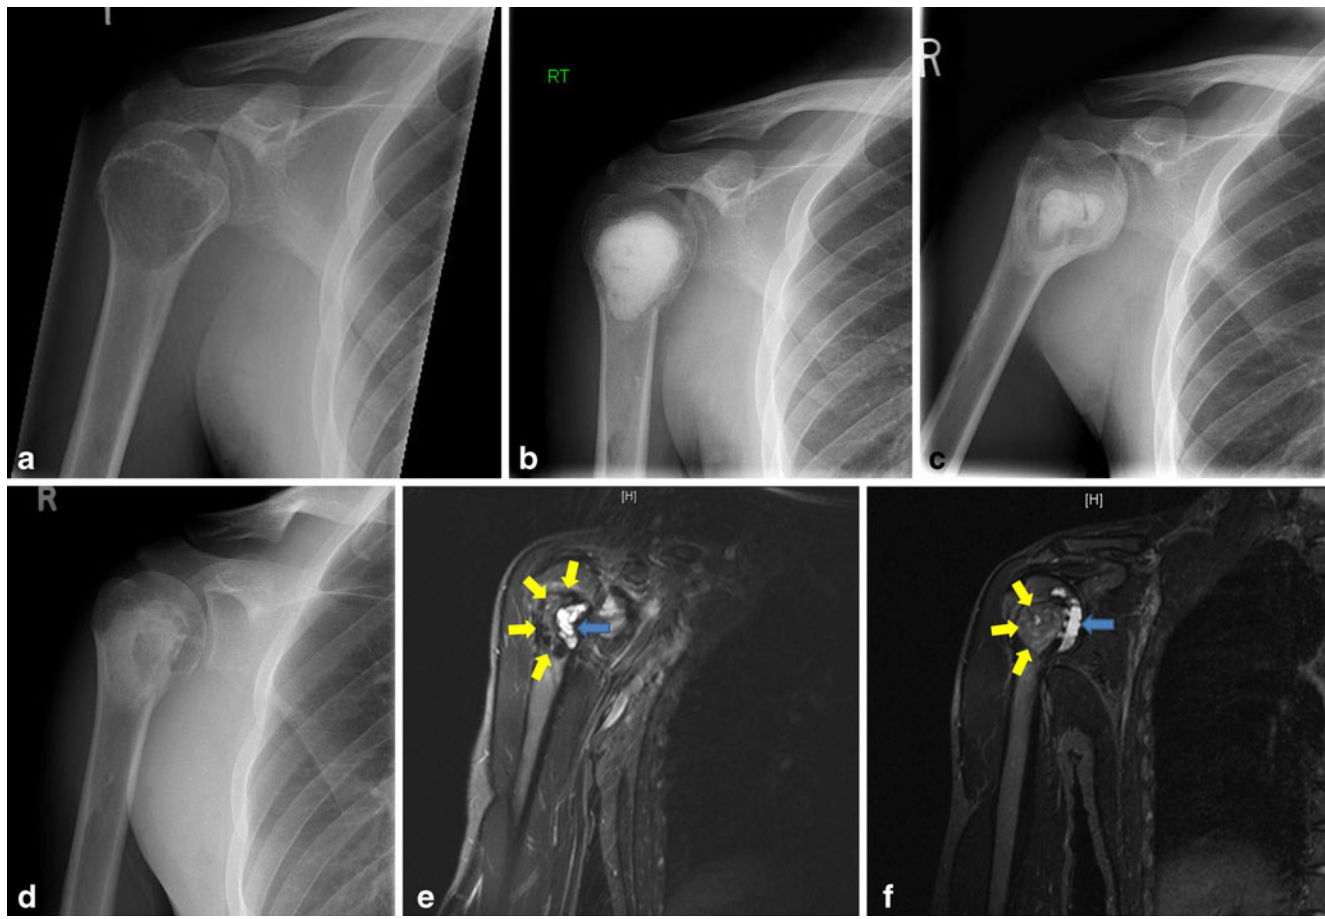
a Pre-operative radiograph of a 26-year-old male with a giant-cell tumour of the humerus with secondary aneurysmal bone cyst formation. Post-operative radiographs at b 1 month and c 6 months demonstrate the expected pattern of peripheral graft resorption. d At 14 months all graft material has been resorbed but a lucent central defect has developed within new bone at the graft site. e and f Coronal
